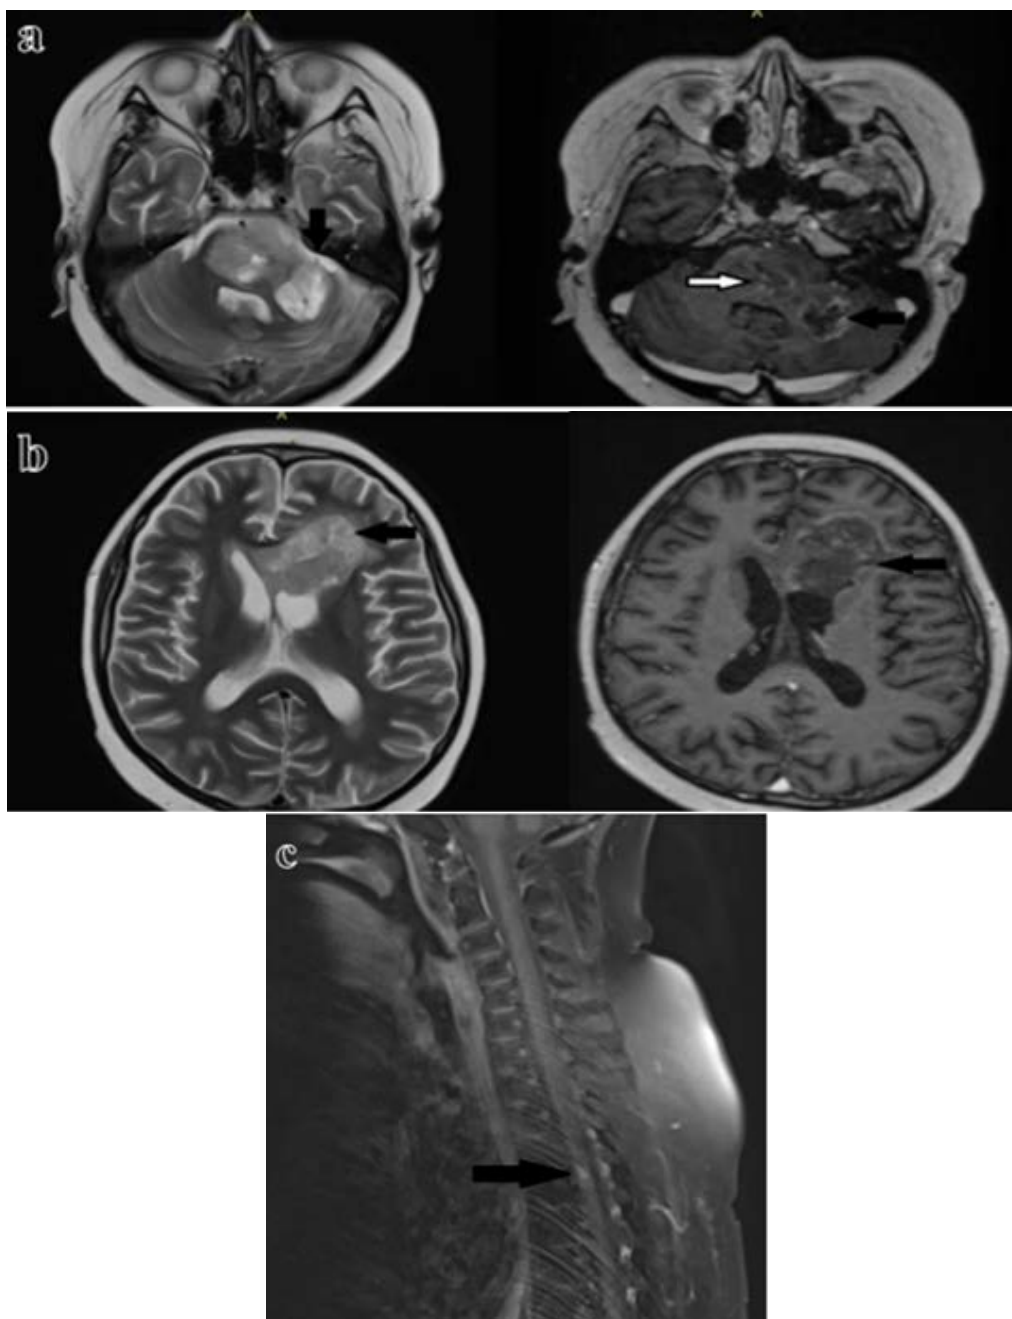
Brain and spine magnetic resonance imaging 6 weeks after radiotherapy. a) Retracted postoperative cavity with a still present postcontrast enhancement of the cavity wall (black arrow, right). Diffuse tumor infiltration within the pons persists (black arrow, left) with a similar postcontrast-enhanced lesion diameter (white arrow, right). b) A frontal lesion with still persistent contralateral spread with volumetric regression (black arrows, left and right). c) A new postcontrast-enhanced nodule appeared at the level of the Th4 vertebral body (black arrow).
